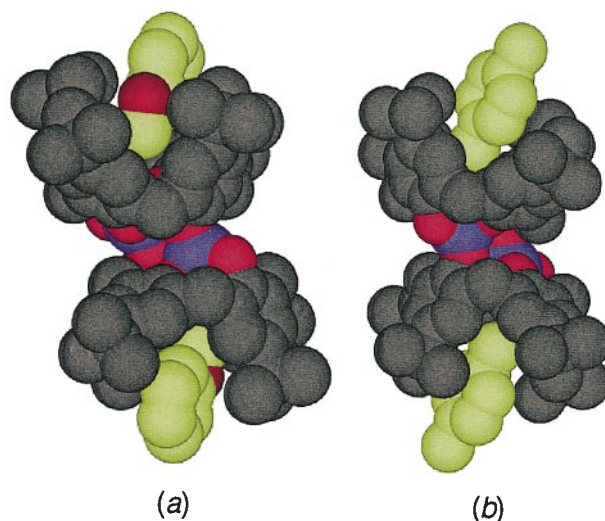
X-Ray structures of discrete binuclear inclusion complexes formed by the linear koiland 12 and anisol (a) and *p*-xylene (b). For the sake of clarity, the carbon atoms of the substrate are coloured in green and the hydrogen atoms are not presented.
